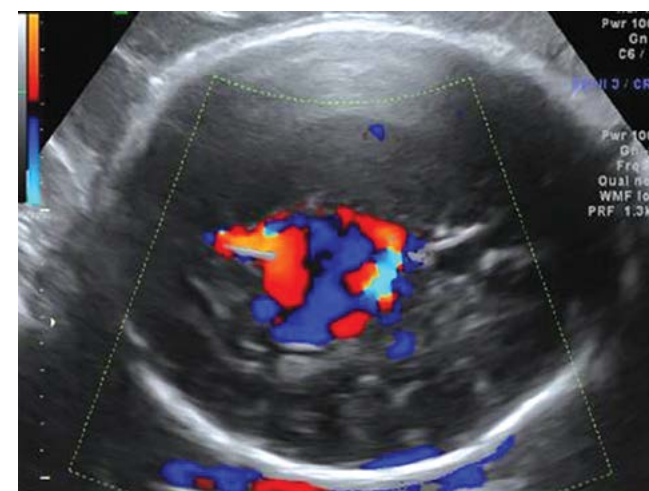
Case two – axial view of the fetal head with colour Doppler
